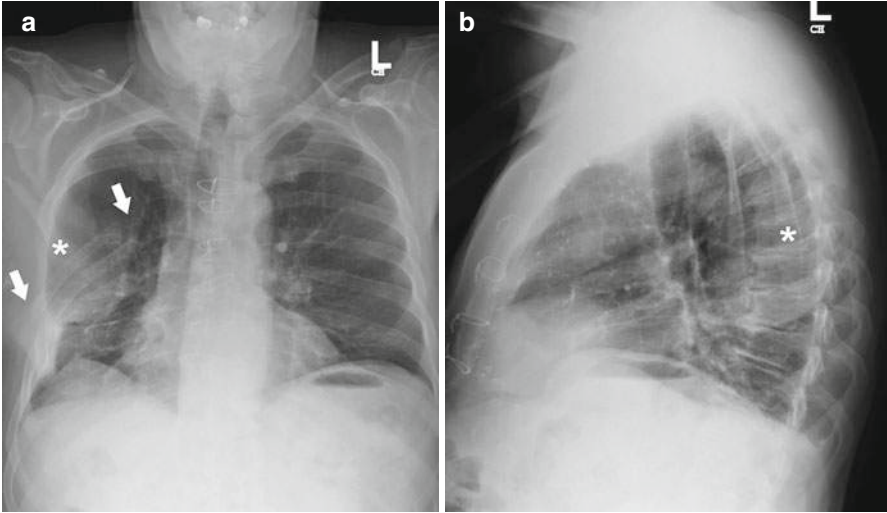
Rib fracture. Chest X-ray posteroanterior (a) and lateral (b) views show multiple rib fractures (*arrows*) and a lung contusion (*star*)
